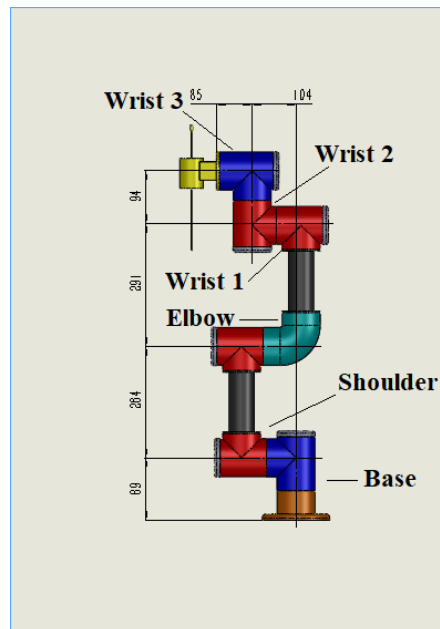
Proposed MRI-guided robot manipulator*
